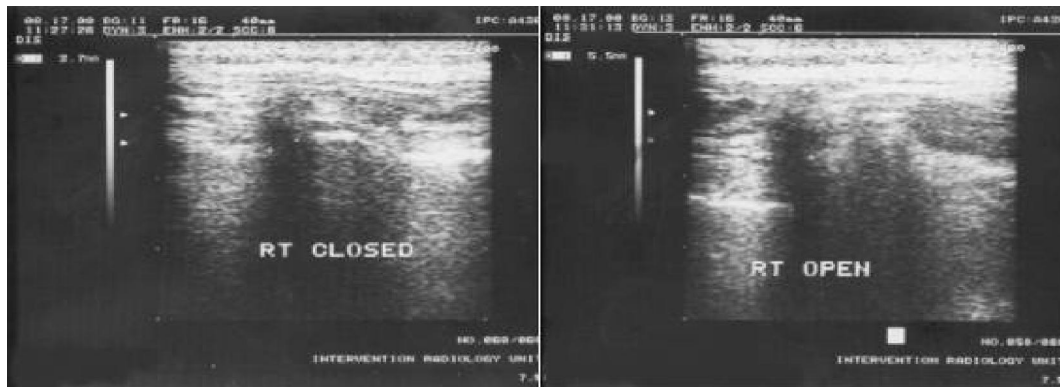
Sonographic scanning for patient in GII showing normal distance between the condyle and the glenoid fossa (= 3.7mm), *left* closed mouth position, *right* opened mouth position (=5.5)
